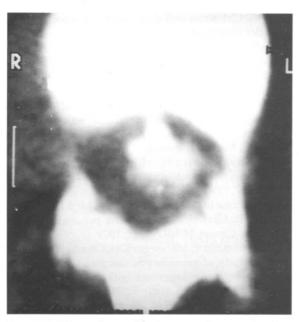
CT-myelography showing the extradural mass compressing the dural sac.
